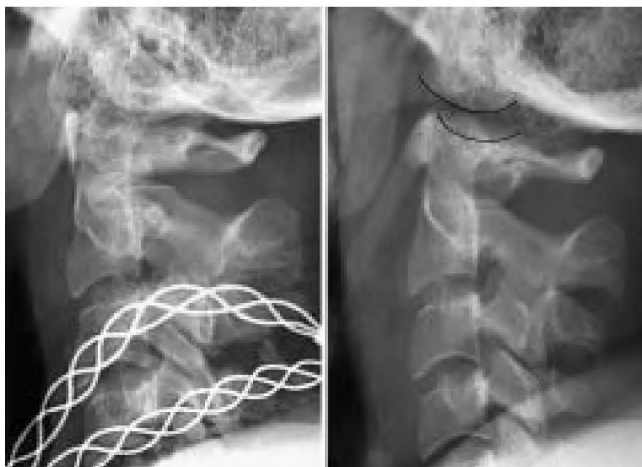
Case 6. Lateral (*left*) and traction (*right*) cervical radiographs documenting mildly displaced Stage 2 CCD; the BDI is within 2 mm of normal, and only mild, unilateral right-sided loss of occipitoatlantal congruence was observed on MR imaging (not shown). The traction radiograph was used to distinguish this as a highly unstable Stage 2 injury (*black lines*) requiring internal fixation rather than a Stage 1 injury in which closed treatment would have sufficed.
